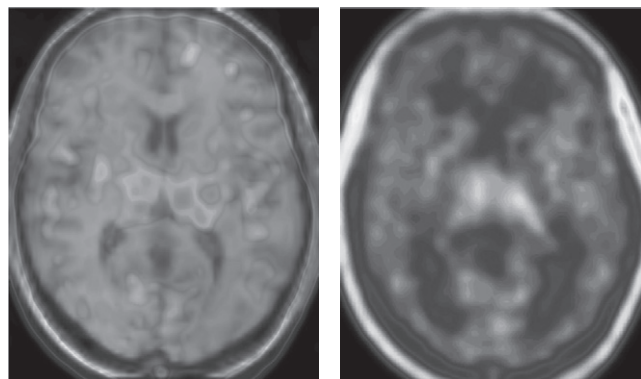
Representative PET parametric image of [¹¹C]PK11195 binding potential (BP) in a healthy individual, superimposed on an MRI (magnetic resonance imaging) template (A); and a [¹¹C]PK11195 PET image from a patient with schizophrenia (B). Note the higher radiotracer uptake in the subject with schizophrenia (in blue color), suggesting the occurrence of neuroinflammatory processes.
